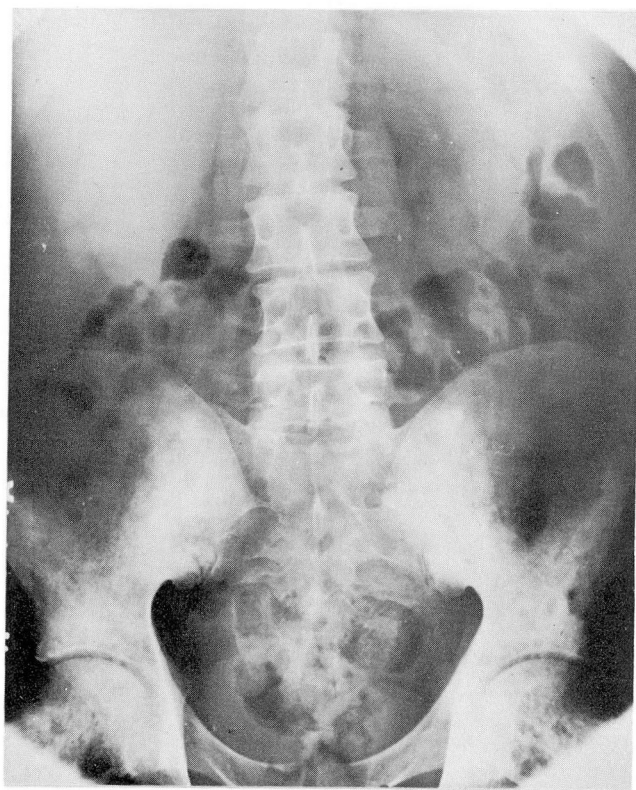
Roentgenogram of the pelvis showing evidence of numerous small islands of osseous loss similar to those observed in the extremities. The vertebrae apparently are not involved.
